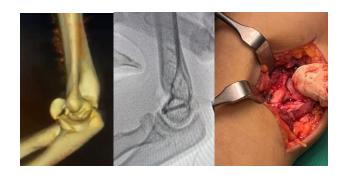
(left): CT scan showing trochlea fracture Figure2(middle): Intraoperative image intensifier showing fracture heal with headless screw
